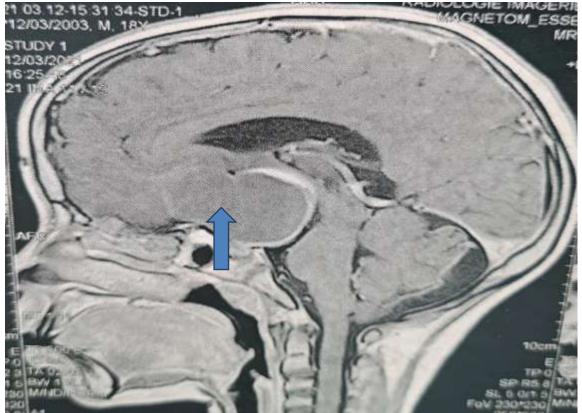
Preoperative encephalic MRI showing a polycyclic suprasellartumoal lesion.
